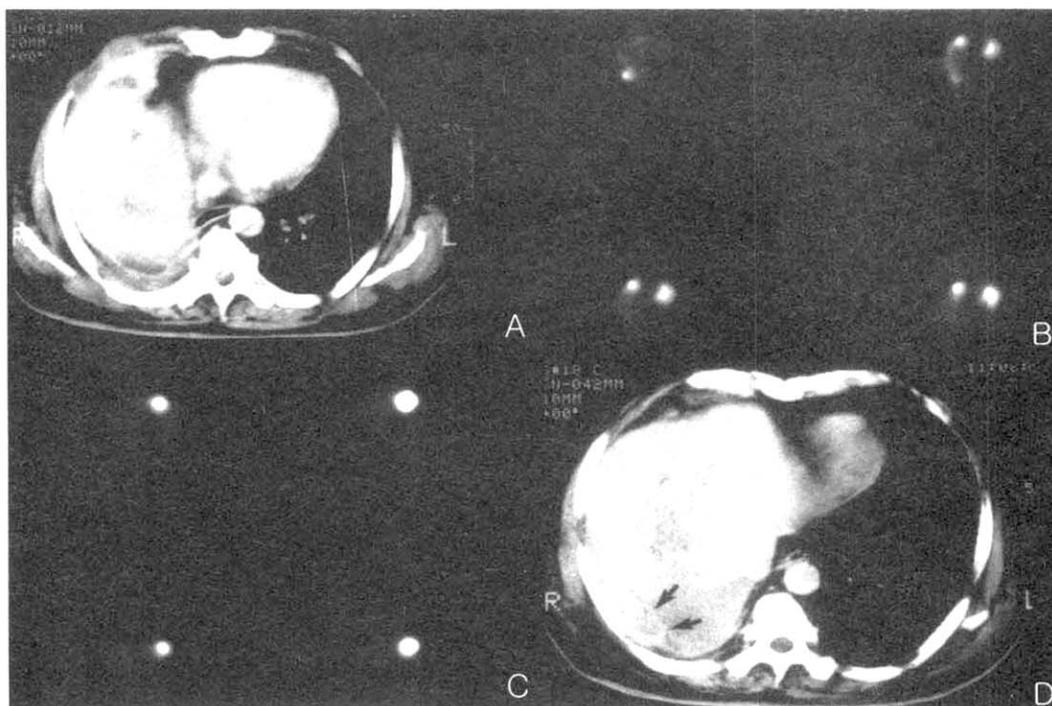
60-year old male patient who had received right pneumonectomy 1 year ago for known squamous cell carcinoma. Postoperative chest CT scan revealed irregular marginated chest wall mass with enhancement on anterior and posterior chest wall (A). 4-hour delayed SPECT images showed grade 3 increased Tl-201 uptakes on anterior and posterior chest wall which were corresponded to chest CT scan abnormalities (B). However, additional focus of grade 3 increased uptake was depicted on lower posterior thorax and meticulous retrospective review of chest CT scan showed another recurrent tumor mass lesion (D). The patient had received radiation therapy for the recurrent tumor mass on the chest wall after initial Tl-201 SPECT, follow-up SPECT 3-4 weeks after cessation of radiation therapy revealed complete disappearance of previously increased uptakes (C).
